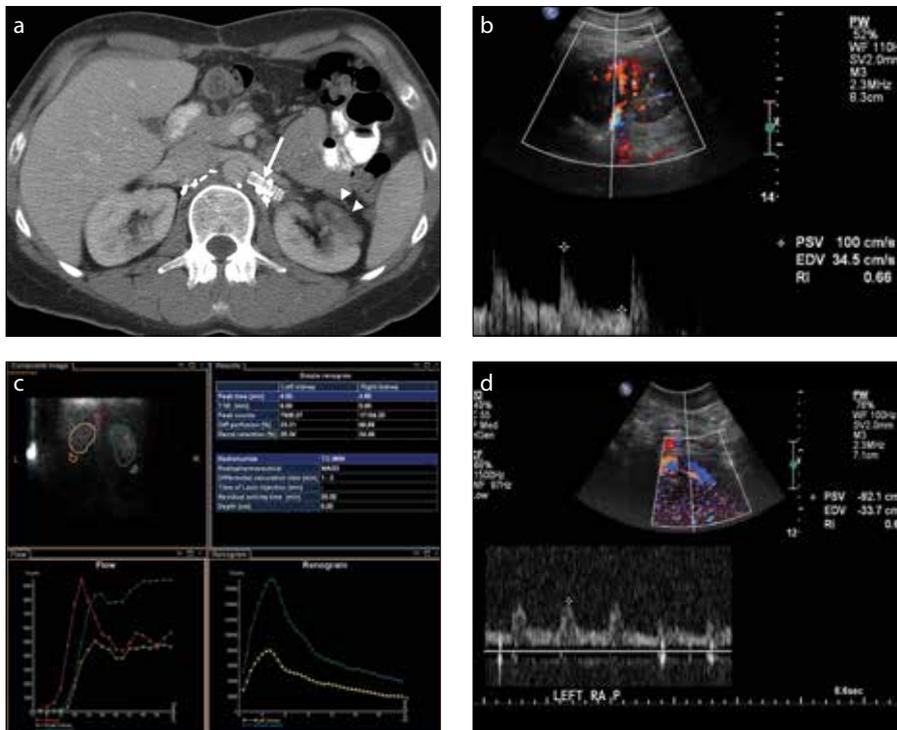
a–d. Contrast-enhanced abdominal CT scan at 3-month follow-up (a) shows patent stent (arrow) with an intact perfusion to the posterior kidney; mild atrophy could be seen involving the anterior cortex (arrowheads). At 20-month postprocedure Duplex US examination (b) demonstrates a patent left renal artery with brisk upstroke and normal parenchymal resistive indices and a MAG3 renal scintigraphy study (c) shows a 2:1 split renal function, with 67% on the right and 33% on the left. Duplex renal ultrasonography 24-months postprocedure (d) shows stent patency, normal resistive indices, patent renal vein, and stable left renal size at 9.4 cm.
